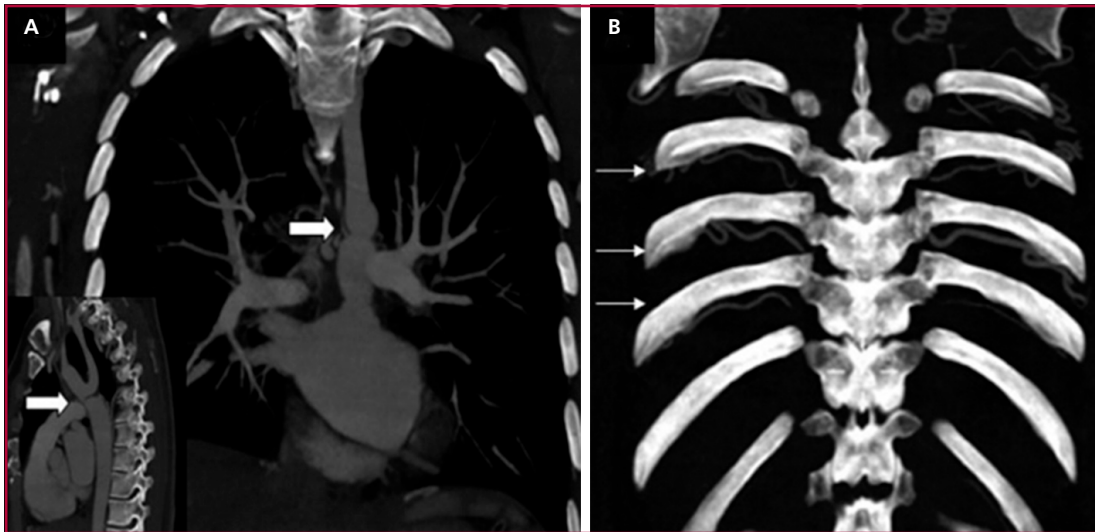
Chest CT angiography: A) Bilateral prominence of intercostal arteries, comprising the inferior borders of the posterior costal margins. B) Coarctation of the descending aorta with prominent pulmonary arteries.
